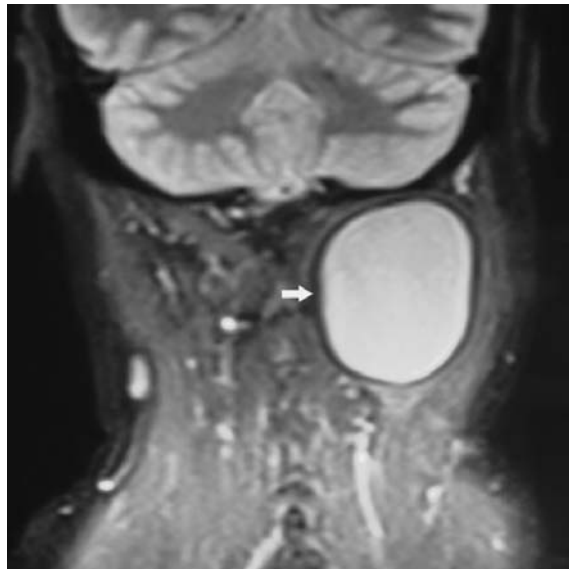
A coronal fat saturated T2-weighted MR image showing well-defined high signal intensity mass with low signal intensity rim (arrow), which is a characteristic feature for hydatid cyst.
